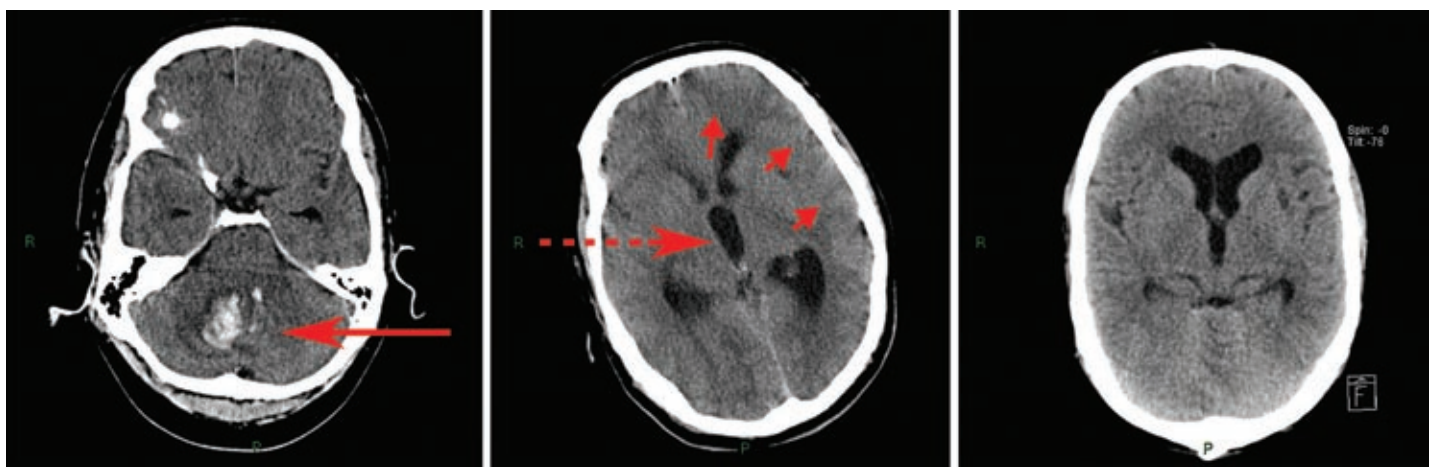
Infratentorial intracerebral haemorrhage. A 40 year old man presented with sudden headache, vomiting, and unsteadiness. On examination his score on the Glasgow coma scale was 15 and he had nystagmus, limb ataxia, bilateral retinal haemorrhages and papilloedema, a blood pressure of 315/180 mm Hg, and proteinuria. Blood tests showed acute renal failure, and he had immediate brain computed tomography, which showed a cerebellar haematoma adjacent to the fourth ventricle (left, arrow). Three days later, his consciousness level fell rapidly, and repeat brain computed tomography showed an increase in size of the third ventricle (centre, dashed arrow) and effacement of cortical sulci (centre, arrowheads) owing to obstructive hydrocephalus. His consciousness level improved rapidly after ventricular drainage and consequent resolution of hydrocephalus (right)
